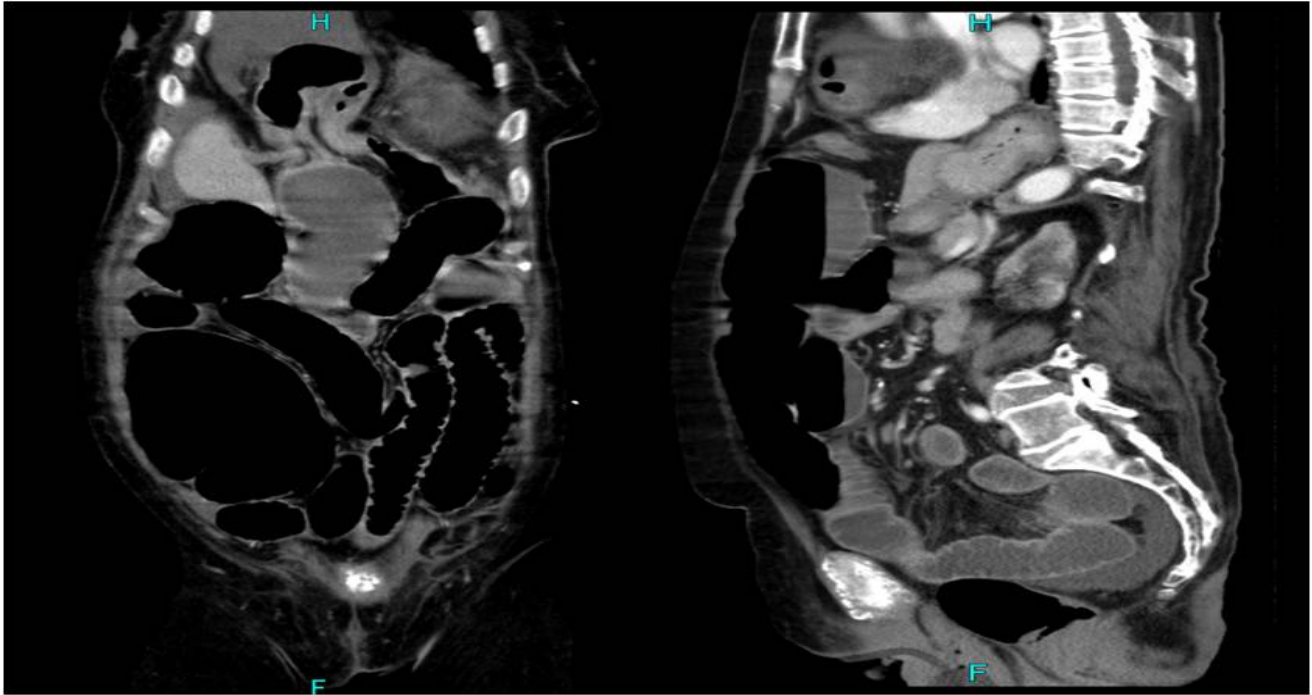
Coronal and sagittal sections of CT scan abdomen showing right sided diaphragmatic hernia with strangulation of transverse colon.
